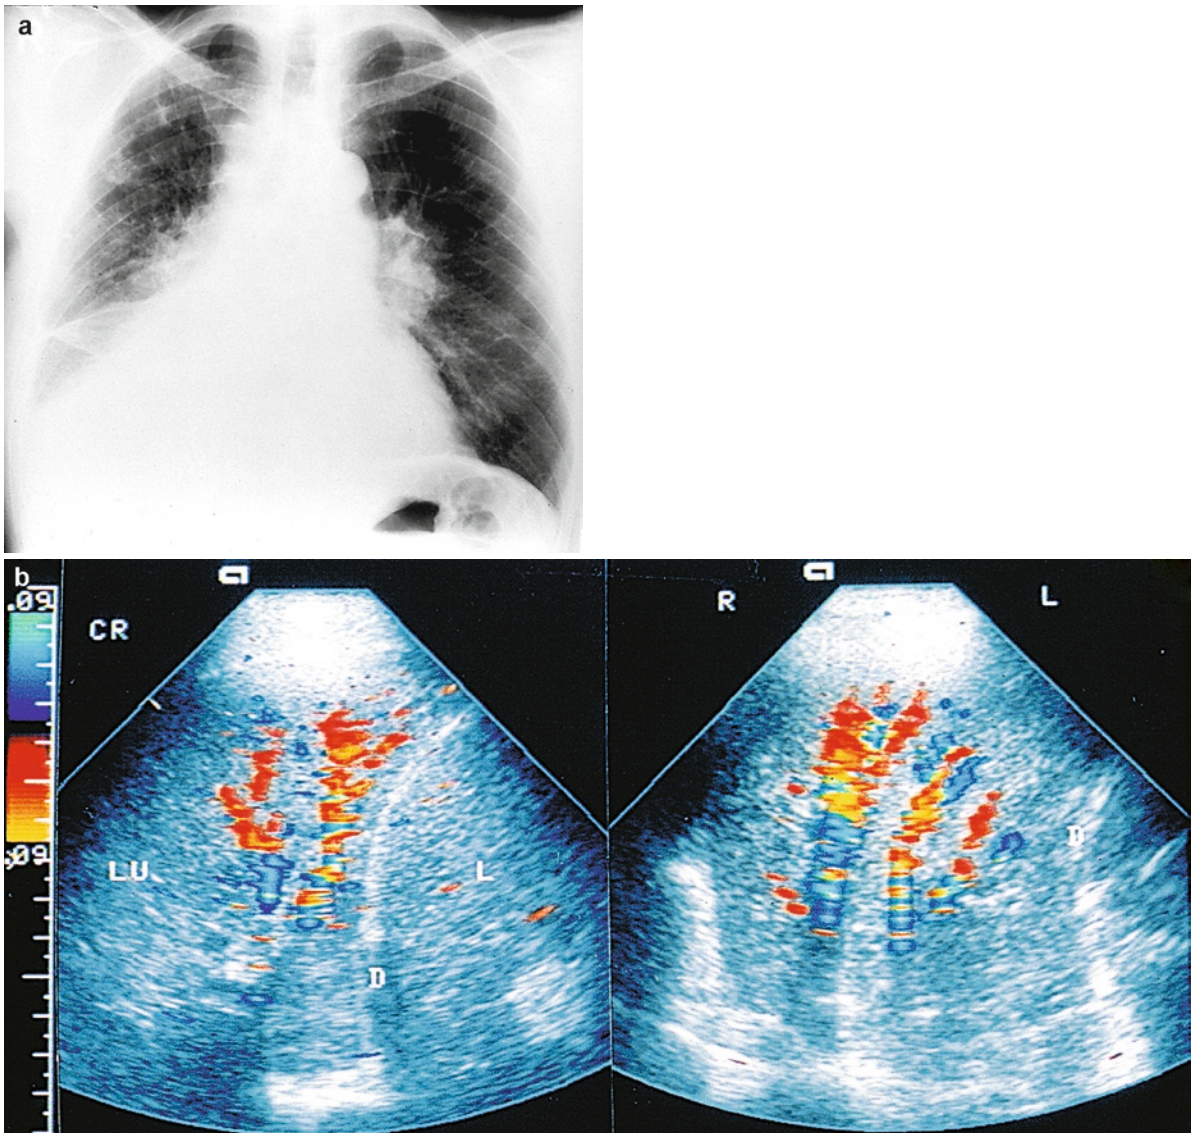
An 84-year-old man with a bronchial carcinoma. (a) Chest X-ray: suspected lower-lobe atelectasis on the right side. (b) Sonography: right-lateral intercostal echo transmission
